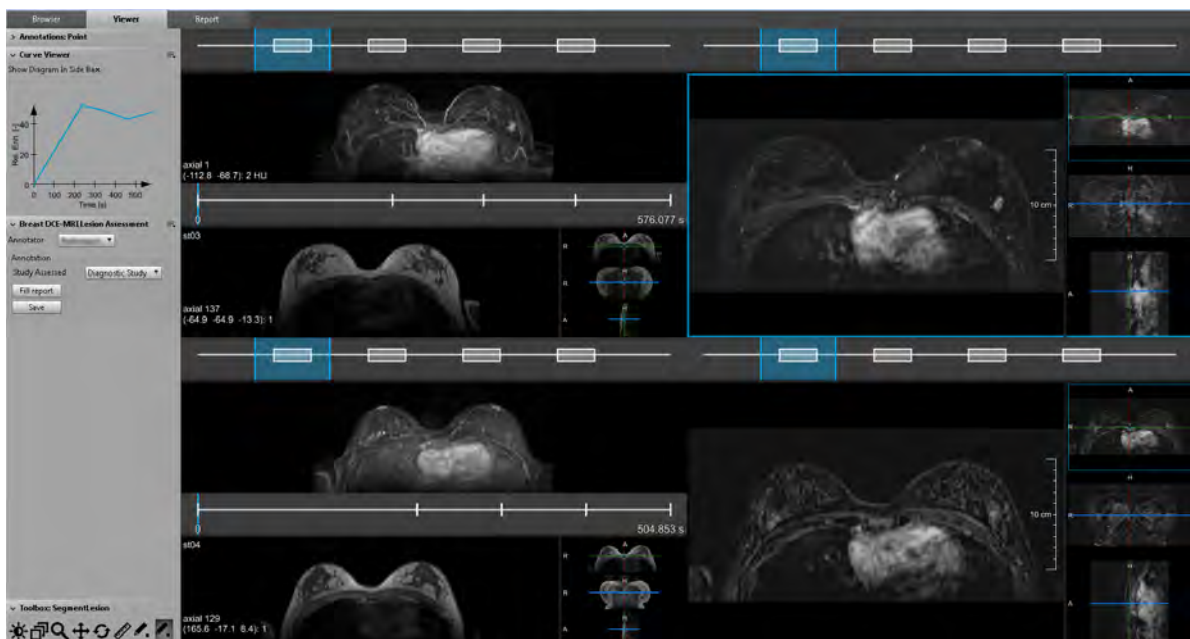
Workstation used in this study for lesion annotation and BI-RADS lexicon reporting in diagnostic (upper row) and prior (lower row) DCE-MRI studies.
